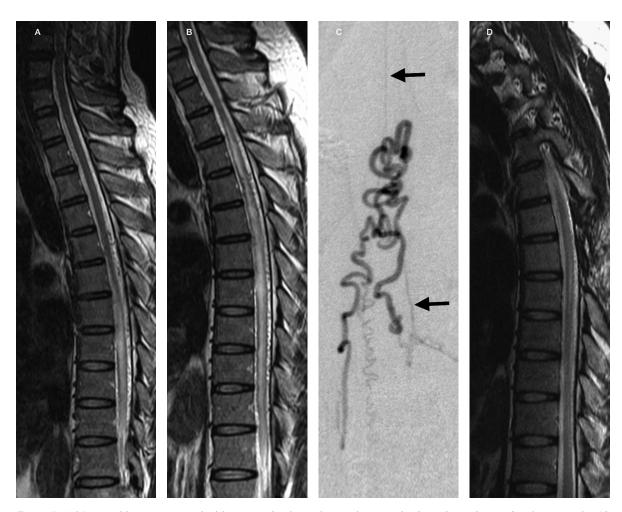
A 34-year-old man presented with progressive lower leg weakness and urinary incontinence for three months. A) Sagittal T2-weighted MR image shows a swollen spinal cord below the T5 level with high signal intensities. B) Note the increased extent of the high signal intensities of the spinal cord up to the T2 level corresponding to aggravation of the neurological deficit following steroid administration. C) Selective spinal angiogram of the left T6 radicular artery reveals a single feeder of the spinal dural arteriovenous fistula. The anterior spinal artery (arrows) arises at the same level as the feeder, which precluded a neurointerventional approach. D) Decreased high signal intensities and spinal cord swelling are noted after surgery with improvement of the neurological deficit seen at the nine month follow-up.
